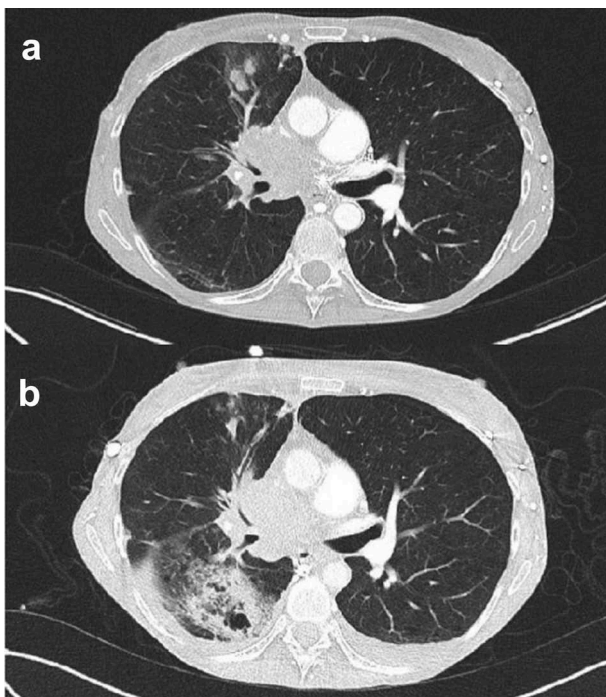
Chest computed tomography (CT) scan before (A) and after (B) the appearance of an excavated lesion in the lower right lobe apical segment.
